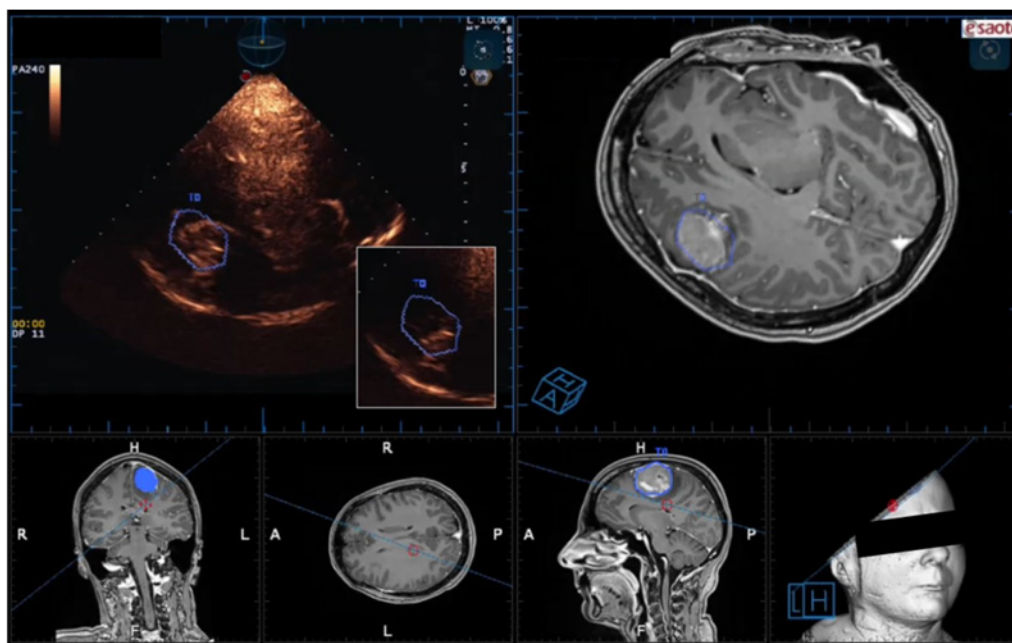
Top row: transtemporal insonation, axial imaging plane, corresponding MRI showing a left-sided meningioma. Note the blue-coded delineation of the lesion in the MRI and the ultrasound image. Top left: Harmonic imaging mode in the phase of contrast bolus arrival (white box = non contrast enhanced image). Note the contrast filling exactly within the delineated borders of the hyperperfused meningioma. Top right: corresponding T1-post contrast MRI, also demonstrating contrast enhancement. Bottom row: 3D-visualization of the chosen imaging plane and partial image of the 3D-surface rendering derived from the MRI.
